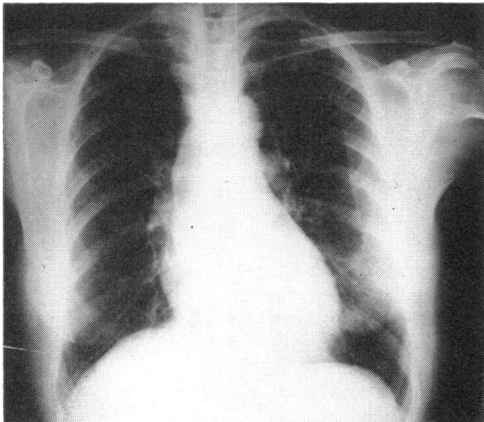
X-ray after initial therapy, showing reduction of heart size and clearing of lungs.
